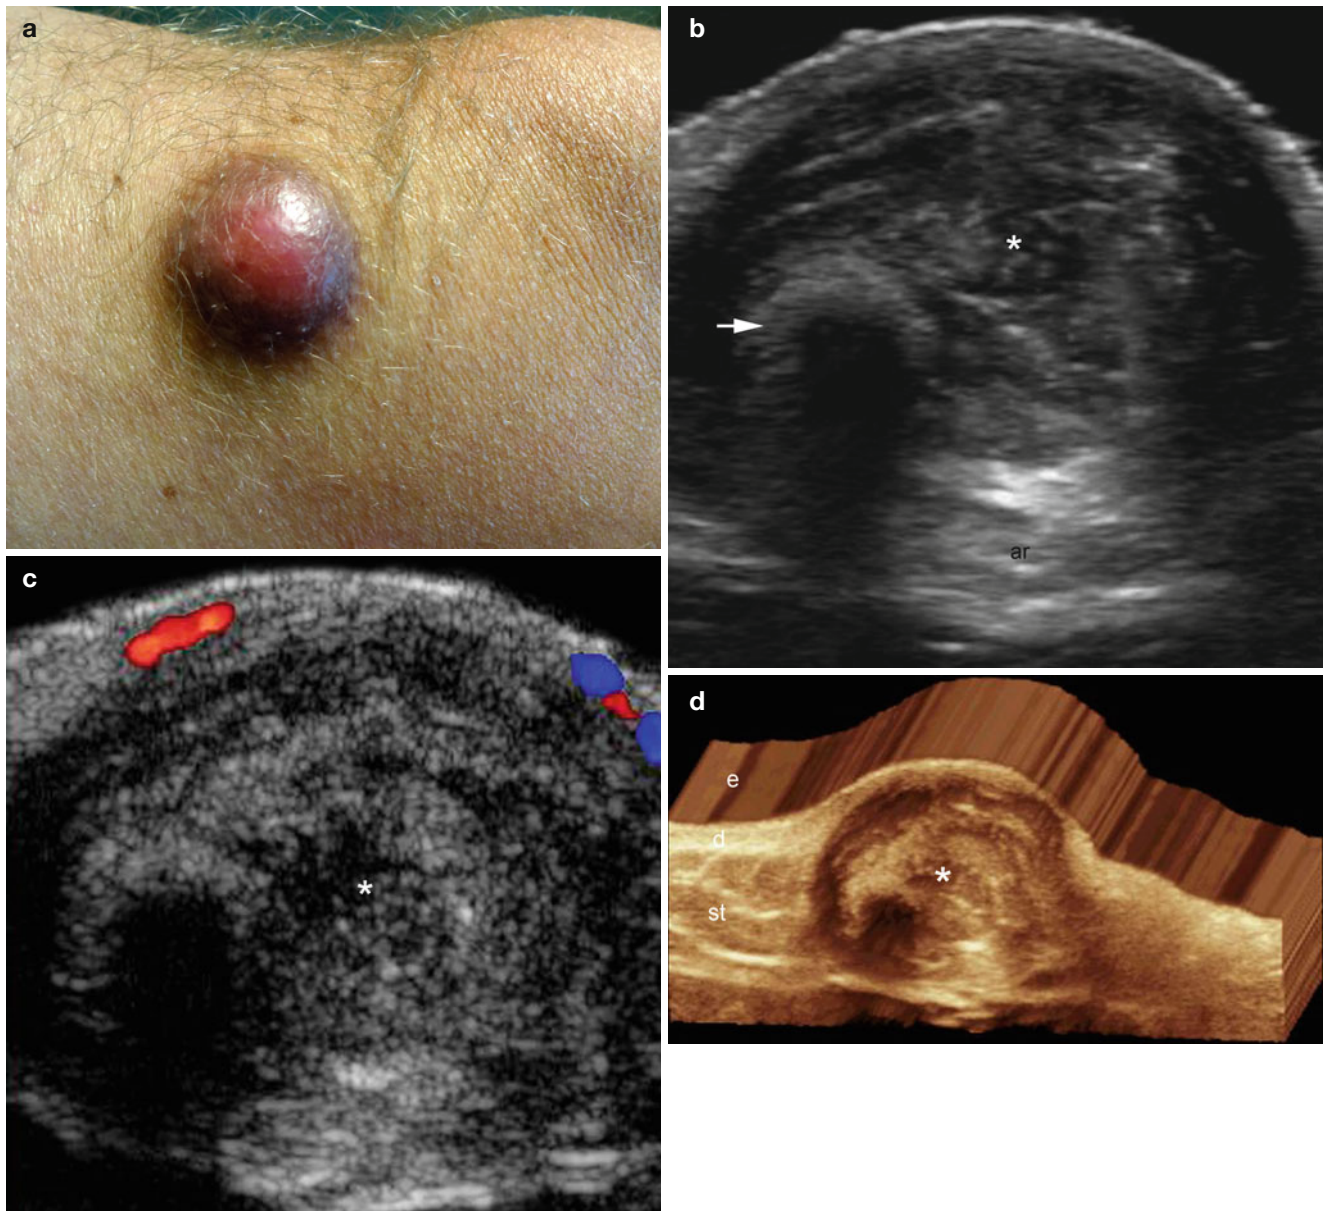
(a–d) Giant inflamed epidermal cyst. (a) Clinical lesion shows an erythematous swelling in the right thigh. (b) Grey scale ultrasound image (longitudinal view) demonstrates a well-defined oval shaped hypoechoic structure (*) located in the dermis and subcutaneous tissue. The hyperechoic spot (*arrow*) in the left aspect of the figure
